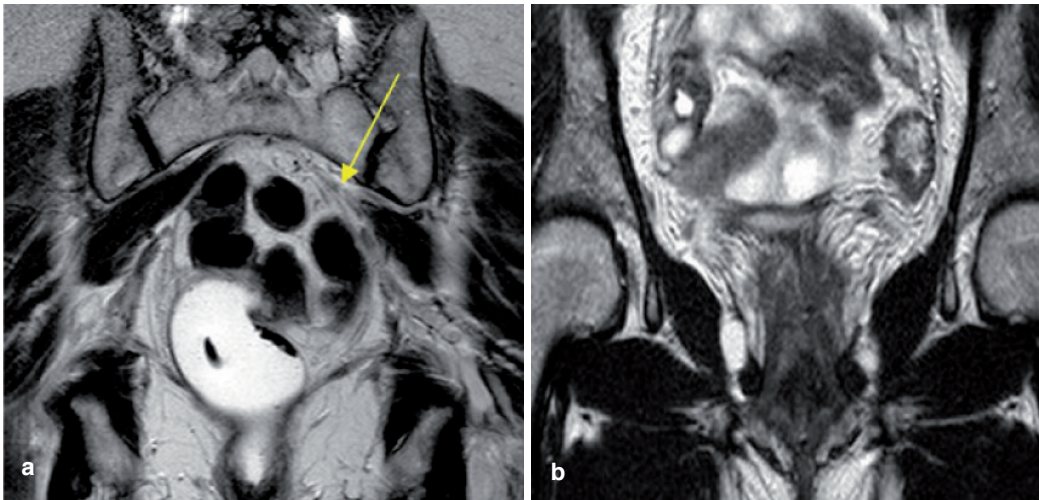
Coronal T2-W MR image obtained in the posterior planes at the level of the greater sciatic foramen and sacral promontory (a): note the asymmetric hyperintense appearance of the left piriformis muscle (arrow) consistent with fibrofatty degeneration which was thought to be responsible for sciatic nerve and pudendal nerve entrapment syndrome in this 39-year old woman with history of intense bike activity. Coronal image obtained slightly anteriorly to a at the level of the acetabular fossa and obturator foramen (b) shows at best the appearance of the obturator internus and externus muscle and the pubococcygeal muscles on either side of the vagina, together with the structure of the perineal membrane.
